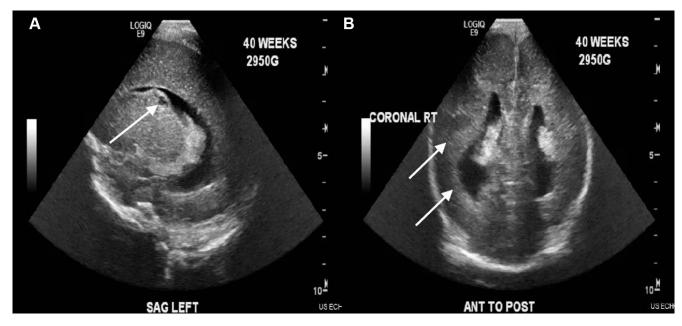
A: Ultrasound encephalography shows abnormal periventricular cysts (arrow) located within the germinal matrix that are most compatible with subependymal cysts/germinolysis and that may reflect sequela of in utero germinal matrix insult. B: Abnormal smooth appearance of the brain with a lack of sulcation (arrows) is consistent with a disorder of neuronal migration such as lissencephaly in this postterm newborn.
